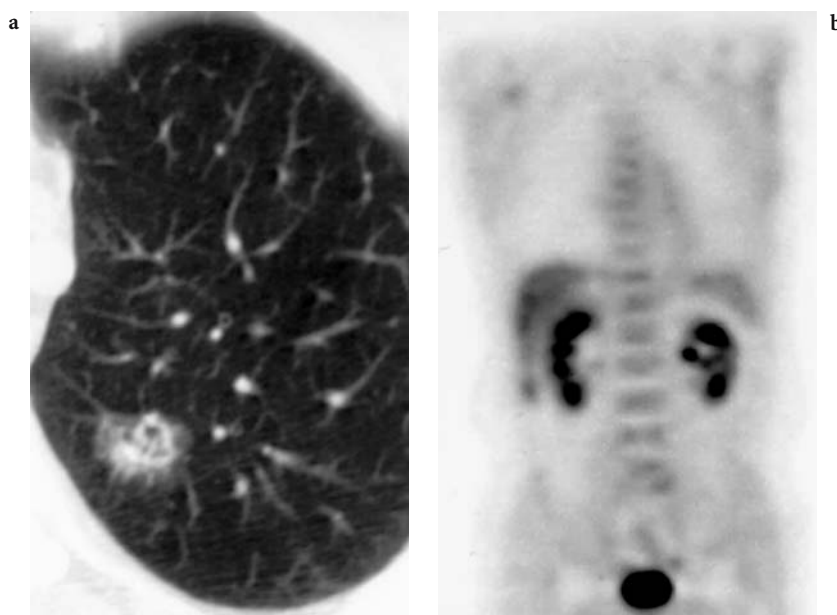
FDG-PET: Stage 1 non-small cell lung cancer. a Axial image through the right upper lobe shows an elongated nodule adjacent to bullae. b Whole body coronal view from a corresponding FDG-PET study shows intense uptake of tracer in the right upper lobe lesion. Note the presence of normal activity in the heart, and renal collecting system. No other foci of increased uptake are apparent. An obvious advantage of FDG-PET for evaluating nodules is the ability to more accurately stage tumors by visualizing remote lesions otherwise not identified by routine CT. Subsequently pathologically proved Stage 1 non-small cell lung cancer
